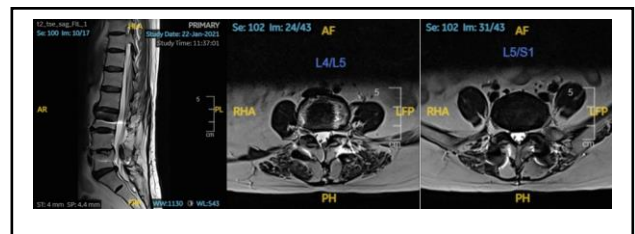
MRI lumbosacral noted foraminal stenosis at bilateral L4/L5, L5/S1 with thickening ligamentum flavum and facet hypertrophy.
